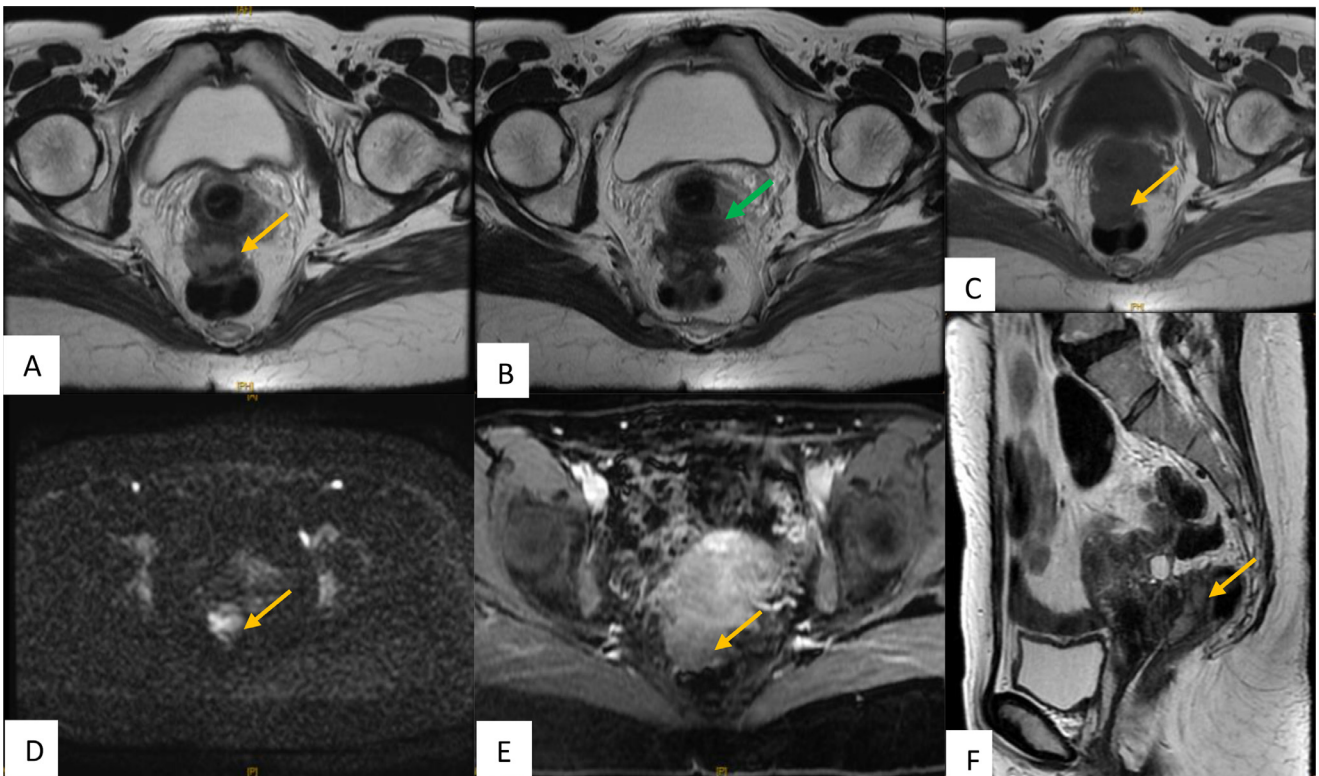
Pelvic MRI control on axial T2WI (A, B), T1WI (C), Diffusion (D), dynamic contrast-enhanced images (E) and sagittal T2WI (F) sequences revealed a lesion in the cul-de-sac (yellow arrow) that was attached to the cervix and invading the anterior wall of the rectum. The mass had irregular contours and showed intermediate signal intensity on T2WI and low signal intensity on T1WI, with restricted diffusion. The dynamic contrast-enhanced images indicated subtle and delayed enhancement compared to the external myometrium, which was attributed to a residual tumor. Additionally, the MRI showed thickening of the torus with hypersignal T2WI (B: green arrow), which suggests endometriosis.
